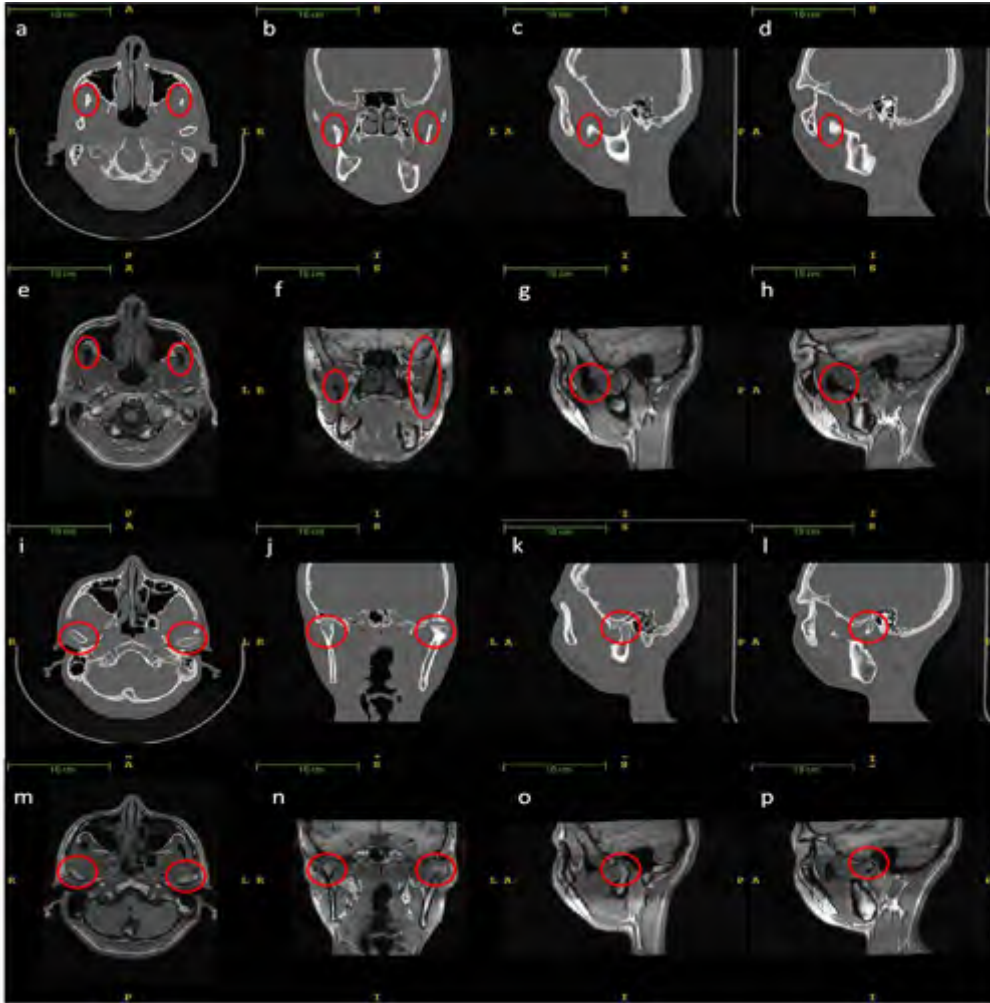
Image quality differences between MSCT and MRI data. The red circles are the regions of interest. (a)-(d) shows coronoid process in MSCT in transverse view, coronal view, sagittal view from left side, sagittal view from right side respectively; (e)-(h) shows coronoid process in the corresponding paired MRI. (i)-(l) shows TMJ in MSCT in transverse view, coronal view, sagittal view from left side, sagittal view from right side); (m)-(p) shows TMJ in in the corresponding paired MRI.
